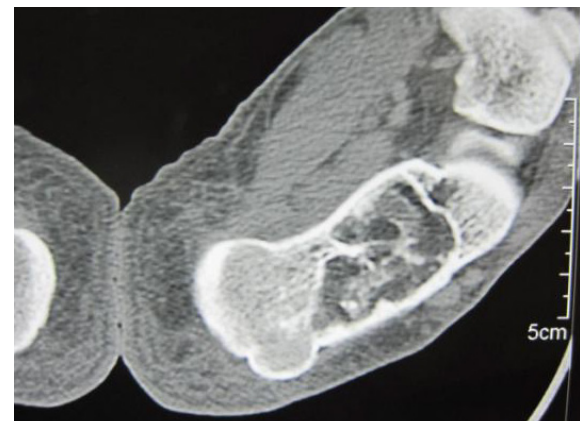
Left side CT scan.
